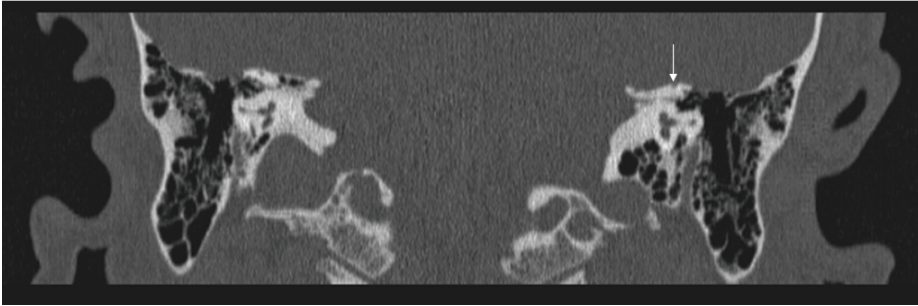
A 0.5-mm Coronal CT scan through the left temporal bone demonstrates dehiscence of bone (arrow) over the left superior canal in 38-year-old male with sound (Tullio phenomenon) and pressure induced (Hennebert's sign) vertigo associated with dehiscence of the arcuate eminence (roof) of the superior semicircular canal.
